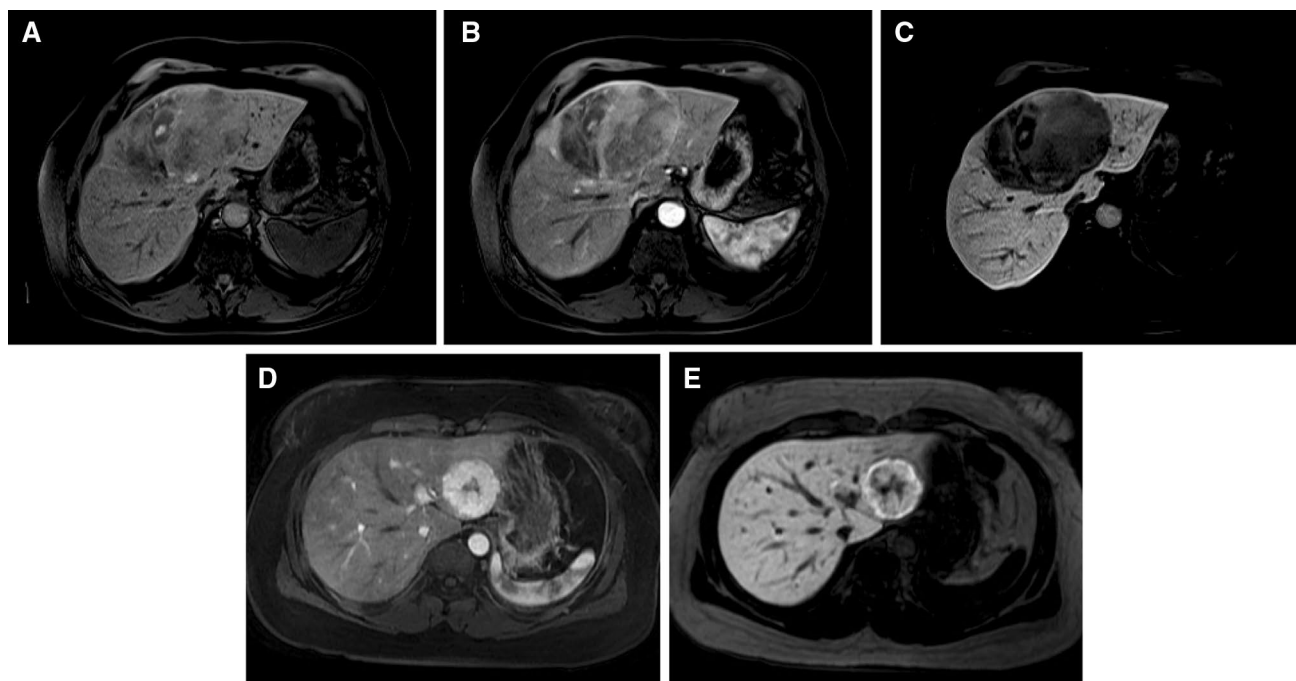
Gadoxetate disodium enhancement. The fat-suppressed T1-weighted precontrast image a shows a mostly hypointense metastasis with hyperintense foci corresponding to hemorrhage. The post-contrast arterial phase image b shows hyperenhancement, typical of an ocular melanoma metastasis. The delayed hepatobiliary phase image c shows stark contrast between the hypointense metastasis (rendered slightly more hyperintense because of the superimposed
